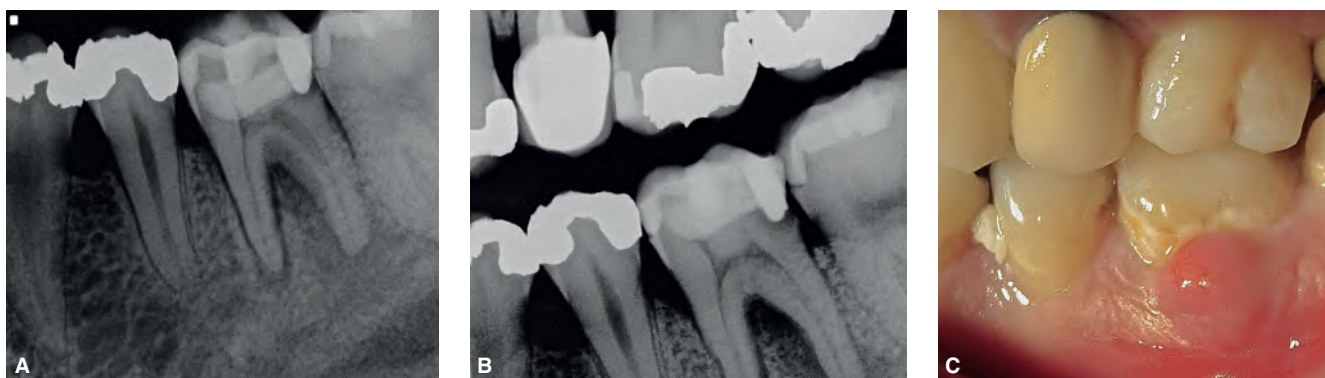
Primary endodontic lesion with secondary periodontal involvement in a mandibular left first molar. A. Periapical radiograph showing a deep coronal restoration with distal caries. B. Furcation bone loss is visible on bitewing radiograph. C. Clinically, a swelling is visible on the buccal attached gingiva of the affected tooth. Pulp sensibility test was negative. Periodontal probing reached the apical third of the distal root. The prognosis of endodontic treatment depends also on the healing of the periodontal lesion.
